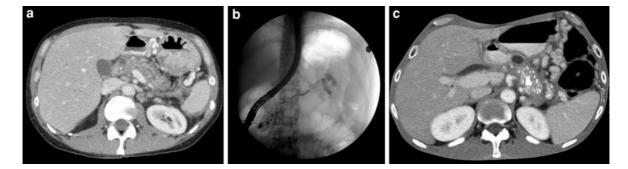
Chronic pancreatitis with associated splenic vein thrombosis. Axial CECT (a) and ERCP (b) images show irregular pancreatic ductal dilatation with dilated side-branches. CT demonstrates isolated gastric varices in the setting of splenic vein thrombosis. Note filling of a pseudocyst near the pancreatic tail on the ERCP image. (1769462); c axial CECT
